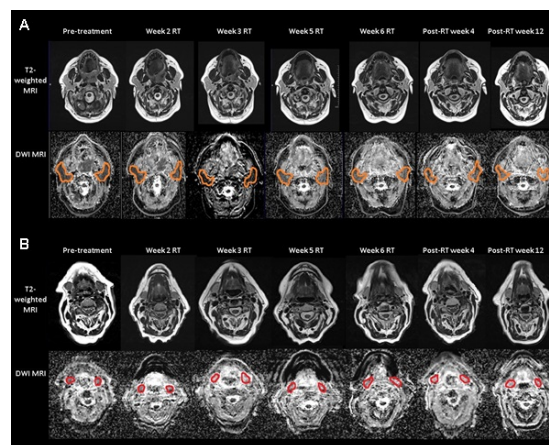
Serial MR (DW and T2-weighted) images of a MPHNC patient with contoured A) parotid glands and B) submandibular glands
